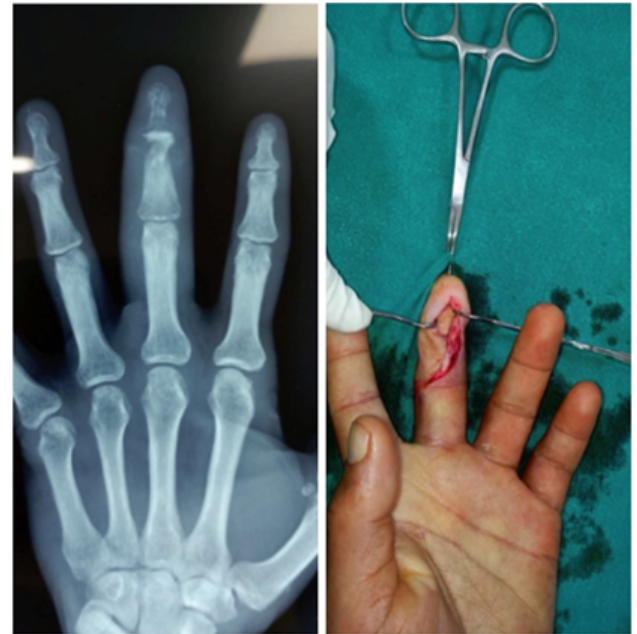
X-ray depicting osteomyelitis of middle phalanx and DIP joint of the left long finger, debridement and replacement of bone cement
